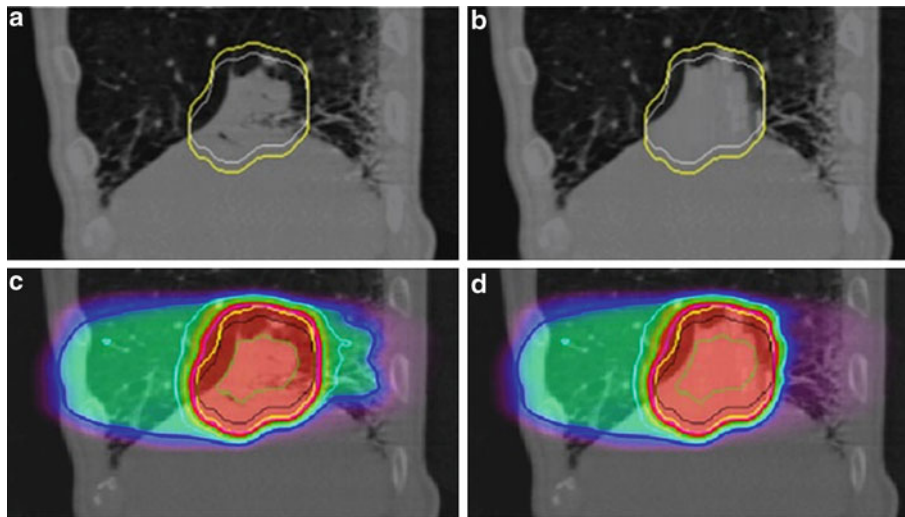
(a) Original CT image at peak exhalation. (b) Image-processed CT image. White and yellow lines show CTV and PTV, respectively. (c) Dose distribution using original CT image. (d) Dose distribution using image-processed CT image
